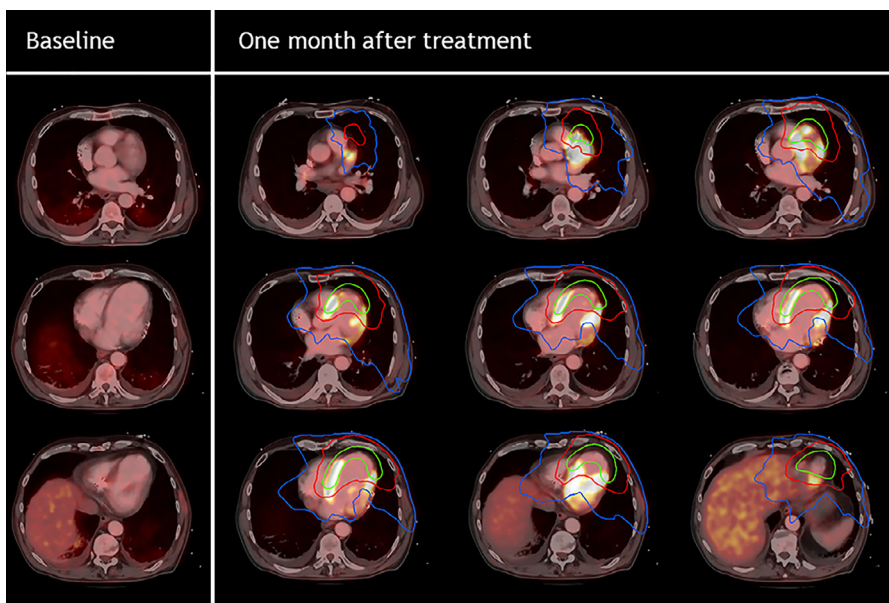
Representative transversal slices of the matched [¹⁸F]FDG-PET/CT scan and the planning CT scan with the isodose lines. In green, the area receiving at least 25 Gy (100%); in red, 12.5 Gy (50%); and in blue, 5 Gy (20%) Increased metabolic activity is also seen in parts of the heart receiving lower radiation doses.
